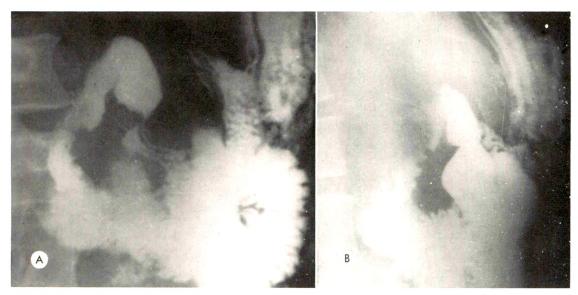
Carcinoma of head and body of the pancreas. (A) Oblique roentgenogram with a large ulceration on the anterior wall of the descending duodenum. The proximal portion of the descending duodenum is deviated anteriorly. (B) The lateral roentgenogram demonstrates the anterior deviation to better advantage. The tumor is mainly posterior to the duodenum, with no enlargement of the loop. Only a portion of the descending duodenum is displaced. Differential displacement such as this is an important diagnostic feature.
